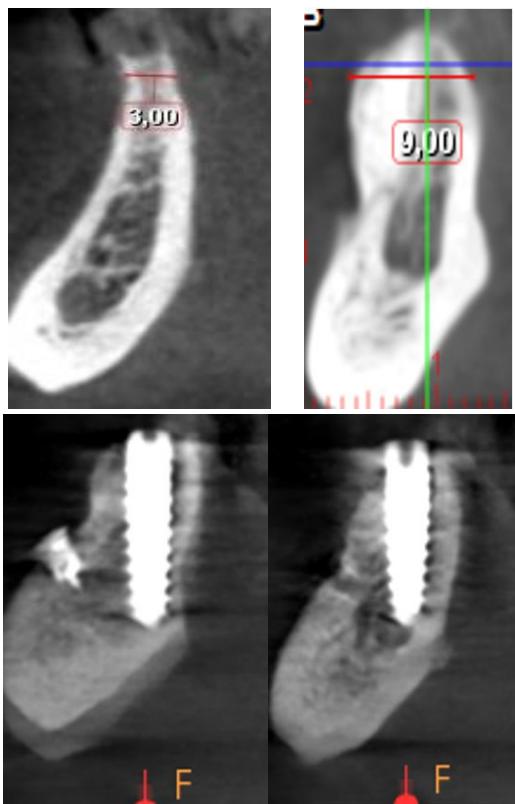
Preoperative and postoperative CT before and after implant placement.
